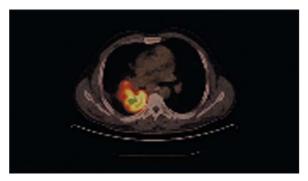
PET-CT reveals SUVmax of 18.8.
